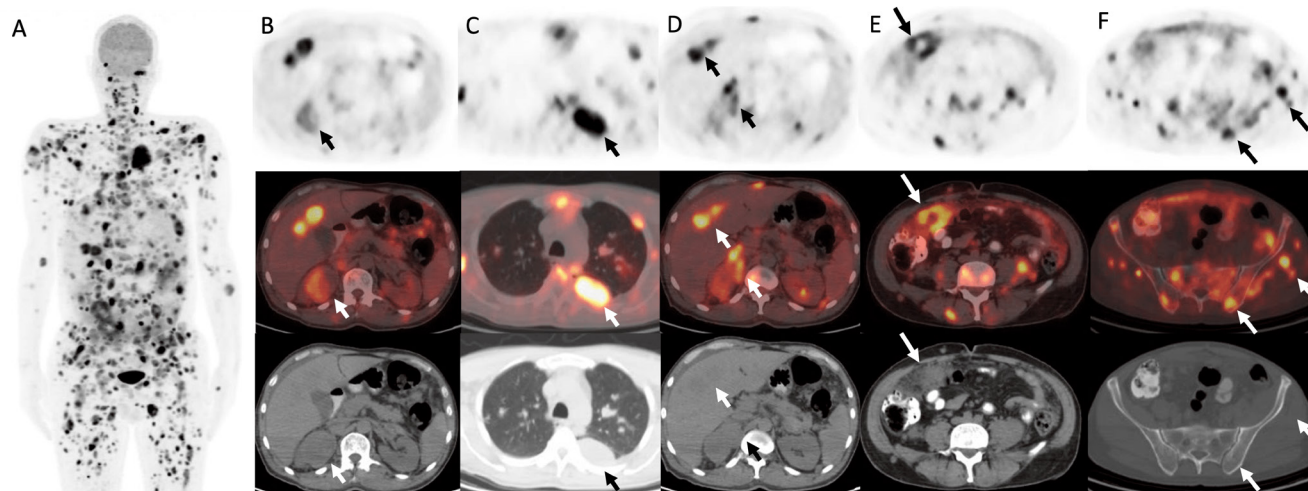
A 53-year-old male patient with no known comorbidity was admitted to the hospital with complaints of fever, night sweats, and fatigue for the last month. Upon detecting a suspicious mass in the right kidney and lung metastases on contrast-enhanced computed tomography (CT), ¹⁸F-fluorodeoxyglucose (¹⁸F-FDG) positron emission tomography (PET)/CT was performed (A) (1,2,3,4). In the PET/CT images, an exophytic localized renal mass in the upper pole of the right kidney exhibited increased ¹⁸F-FDG uptake [maximum standardized uptake value (SUV_{max}): 5.5], which was considered suspicious for renal cell carcinoma (RCC) (B, arrows). In addition, multiple hypermetabolic parenchymal and pleural lesions in bilateral lungs (SUV_{max}: 11.9) (C, arrows), bilateral adrenal glands (SUV_{max}: 9.5) (D, arrows), liver parenchyma (SUV_{max}: 10.0) (D, arrows), peritoneum (SUV_{max}: 8.7), mesentery (SUV_{max}: 13.1), and omentum (SUV_{max}: 11.1) (E, arrows), multiple bone metastases (SUV_{max}: 12.1), and soft tissue lesions in subcutaneous tissue and muscles (SUV_{max}: 14.6) (F, arrows). All lesions that could not be distinguished on CT images were distinguished on PET/CT images. A biopsy of the renal mass revealed papillary RCC (pRCC). A few days later, after pathological diagnosis, the patient was taken to the hospital because of worsening general condition and died in the intensive care unit due to hemodynamic deterioration. pRCC has a better outcome in localized disease than clear cell RCC (ccRCC). However, metastatic pRCC is associated with higher recurrence rates and lower survival than ccRCC (5). Moreover, various studies have reported that a higher SUV_{max} or presence of metastatic disease indicates shorter survival (6,7,8). Therefore, ¹⁸F-FDG PET/CT is an efficient method for staging RCC, primarily for estimating the tumor load of metastatic disease.
